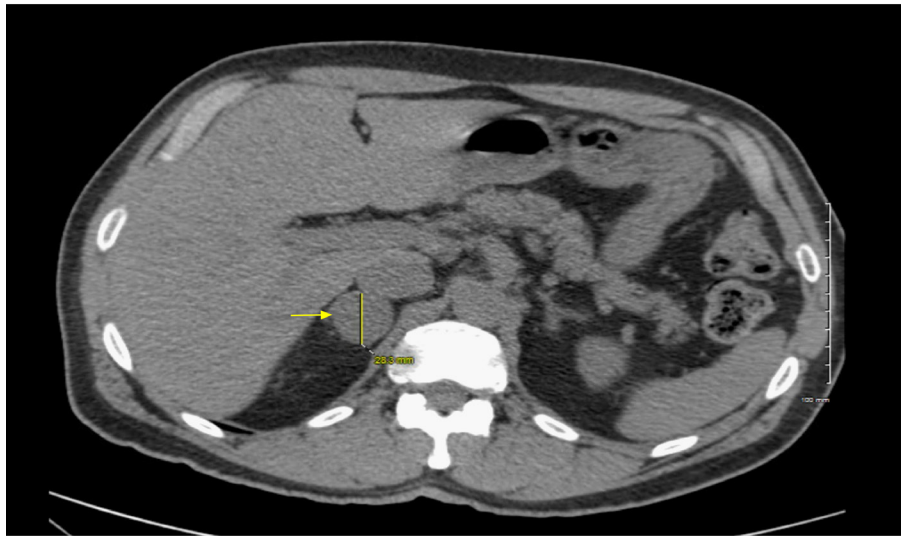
Non-contrast CT scan of the abdomen, depicting 2.8-cm right adrenal nodule (arrow).
